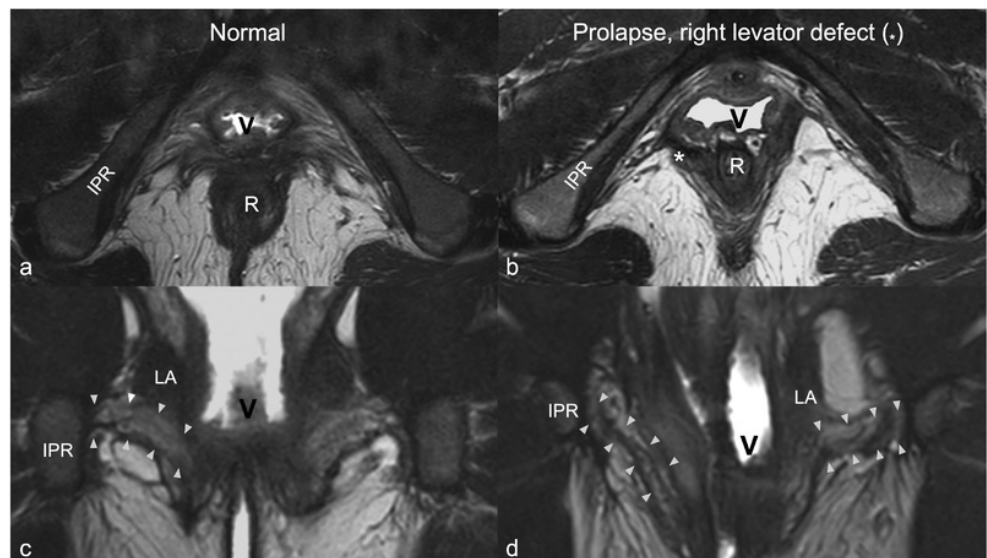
Axial (a,b) and coronal (c,d) MRI scan comparison between nulliparous woman (a,c) and young woman with prolapse with right levator avulsion (b,d). Note the marked asymmetry left/right in the prolapse woman caused by architectural distortion associated with levator defect (*), and caudal angulation of PM (between white arrowheads). Abbrev.: V, vagina; R, rectum; IPR, ischiopubic ramus; LA, levator ani muscle.
